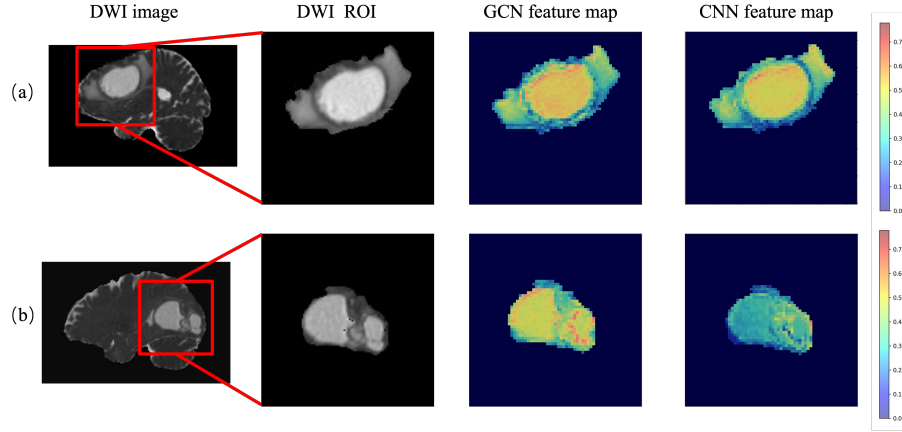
Visualization results of classification feature maps using Graph and CNN-based methods. Rows (a) and (b) correspond to two patients from the test set. The "DWI image" column presents the tumor structure of each patient, while the "DWI ROI" column highlights the tumor region. The "GCN feature map" and "CNN feature map" columns show the extracted feature maps of the tumor region using the Graph and CNN-based methods, respectively. The red-highlighted areas indicate the key regions of interest for the models.
